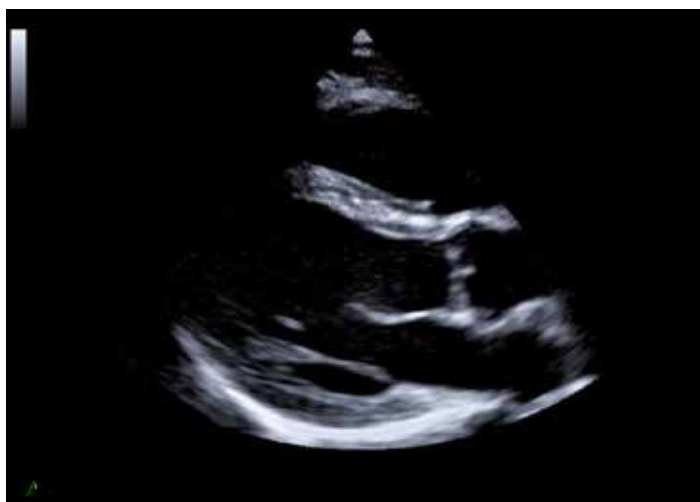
Parasternal long axis (PLAX)
